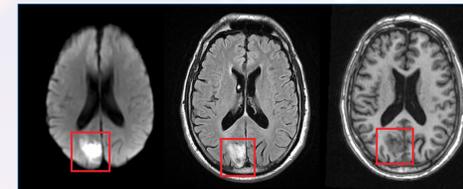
The differing appearances of the same brain through various MR sequences. Note the stroke lesion on the right cerebral hemisphere towards the back of the brain as indicated in the red box, and how the lesion presents differently in different MR modalities. From left to right: Diffusion-weighted image (DWI), fluid-attenuated inversion recovery MRI sequence (FLAIR) and T1-weighted MRI sequence (T1W).
